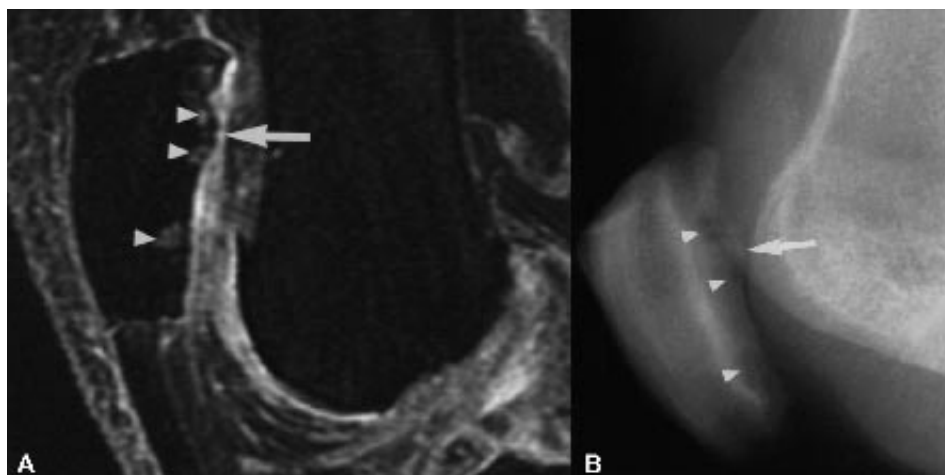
A B 54-year-old woman with central osteophyte at patella. A, Sagittal fat-suppressed three-dimensional spoiled gradient-echo MR image (TR/TE, 40/6; flip angle, 40°) shows subarticular osteophyte (arrow) with extensive articular cartilage loss at patella and trochlear groove and underlying foci of increased subchondral signal (arrowheads). B, Lateral radiograph shows subarticular osteophyte (arrow) with subarticular lucencies (arrowheads) corresponding to subarticular signal abnormalities shown in A.
